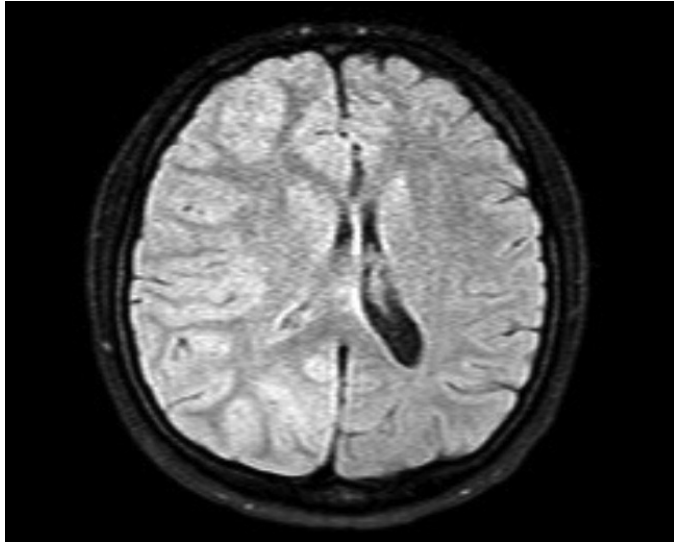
Axial FLAIR-weighted MRI (TR4836, TE100, FA90): In the regions mentioned in Figure 1, mild hyperintense signal changes, increased thickness of the gyri, and mild flattening of the accompanying sulcal structures are observed. Slight flattening of the right lateral ventricular contour and slight shift of the midline structures to the left predominantly in the subfalcine area are observed
